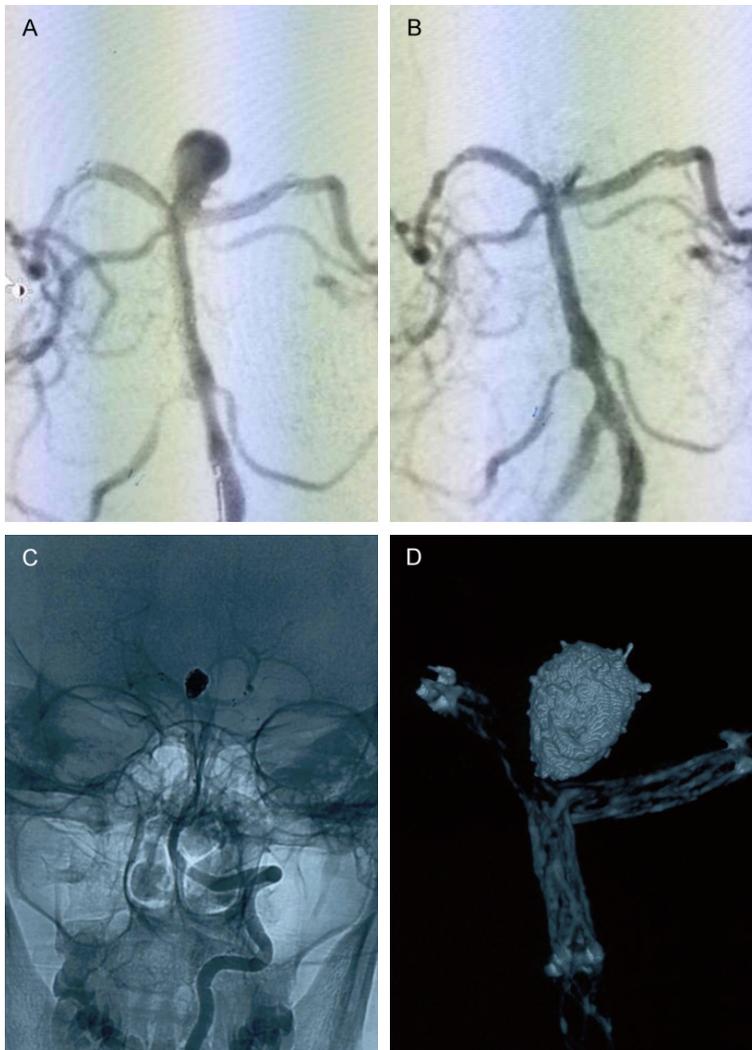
Intraoperative angiography. A. Angiography shows an aneurysm at the top of basal artery. B. Postoperative angiography of Y stent assisted coiling. The aneurysm is barely visible; the blood flow of the bilateral posterior cerebral artery and basal artery is not blocked, and no thrombosis is present. C. Postoperative imaging without subtraction. D. Postoperative Vaso CT shows the relationship between the Y stent and coil. Both stents were in good position.
